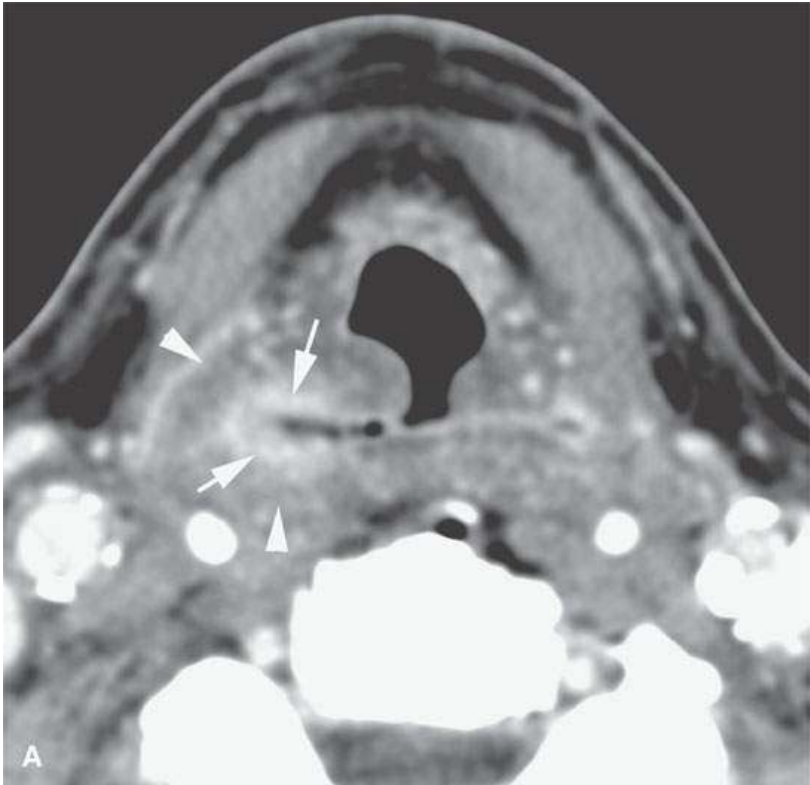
Contrast-enhanced computed tomography (A, B) shows a mucosal mass (*arrows*) and much surrounding swelling (*arrowheads*) as findings that are very suspicious for persistent at 3 months following completion of radiotherapy.[SF3] Recurrence was confirmed by biopsy.
